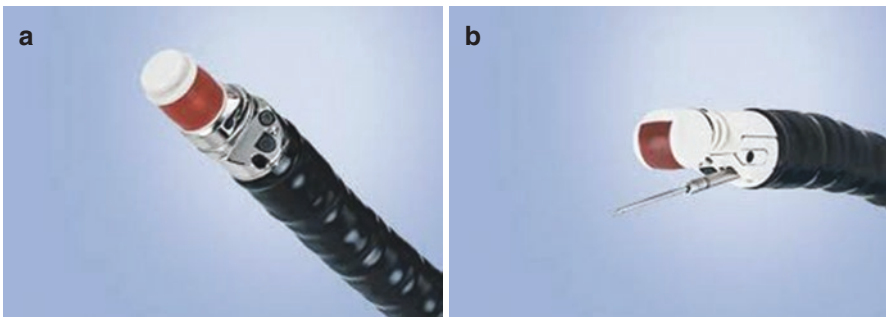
(a) Tip of a radial echoendoscope. It bears an ultrasound probe which may scan a 360° plane vertical to the shaft of the echoendoscope. (b) Tip of a linear array echoendoscope. It bears an ultrasound probe which may scan an axe-like plane parallel to the shaft of the echoendoscope, enabling real-time visualization of aspiration/biopsy needles (Courtesy of Olympus Corp)
